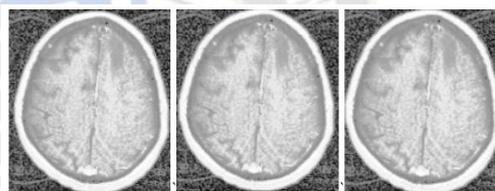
Glioma MRI image using HE [self]
